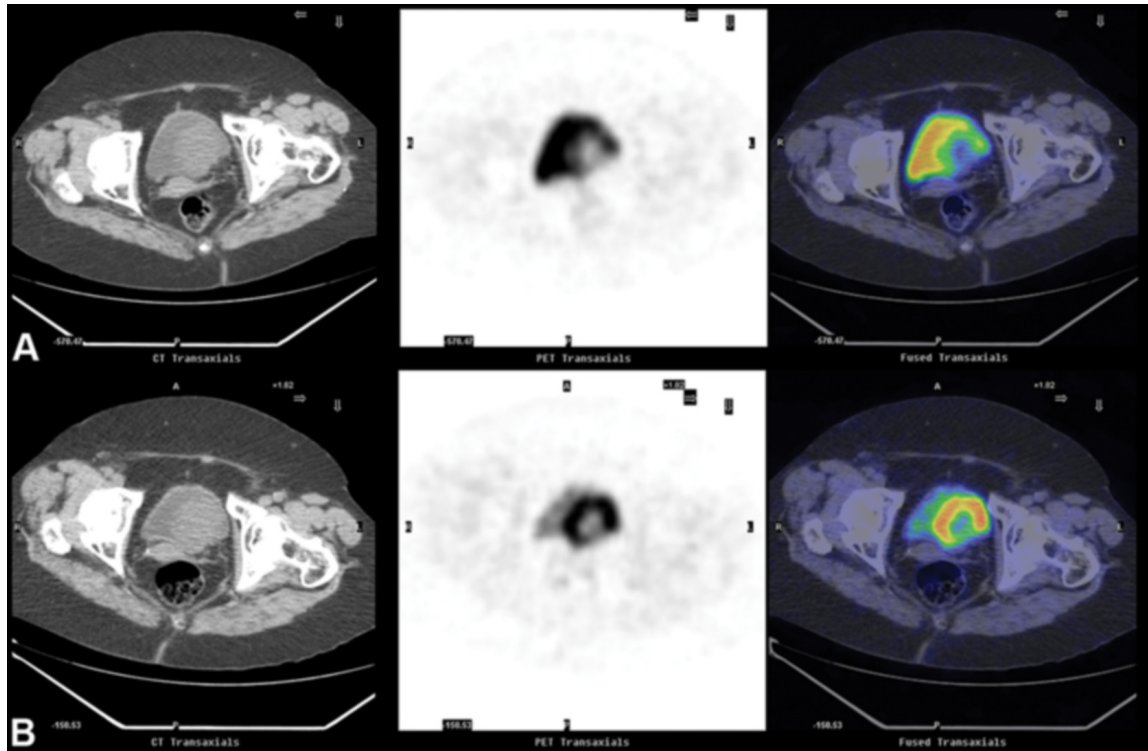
79-year-old woman with suspected recurrence of urothelial cancer. Transaxial images at the bladder level, CT scan, PET scan, and fusion. A. At one hour post injection, PET shows a “minus” inside the bladder. B. At two hours post injection, the tumoral lesion is clearly evidenced by greater (18F)-FDG uptake than the background.
